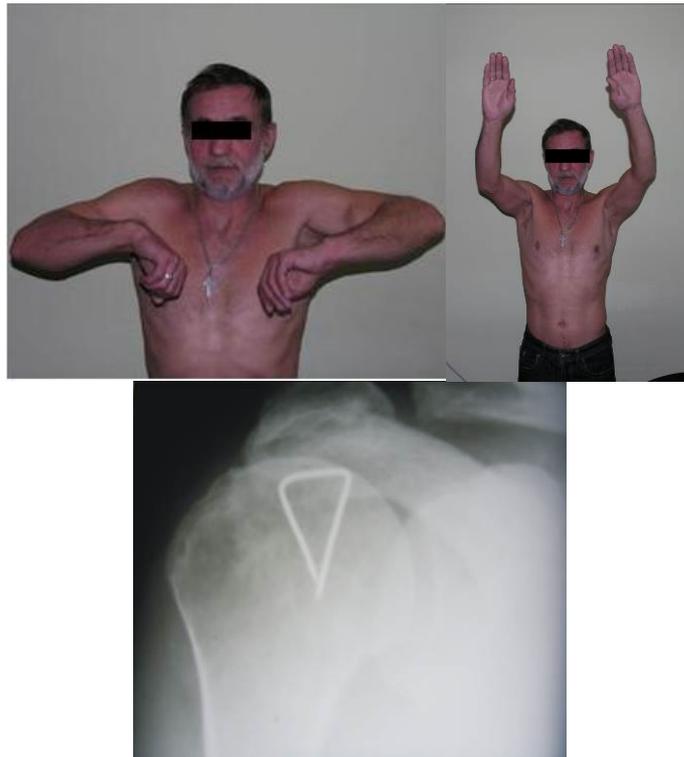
Patient P., 51 years after 1 year after the operation, the amount of movement in the joint is full, a good result. At the head of the humerus (radiographically determined bracket of nickelid titanium)
